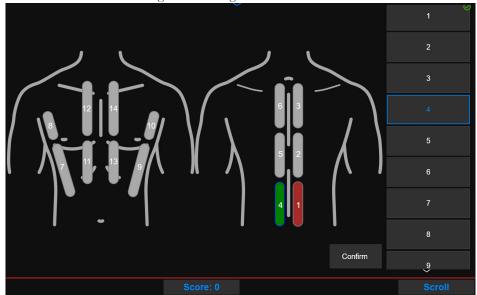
Lung Ultrasound Score
